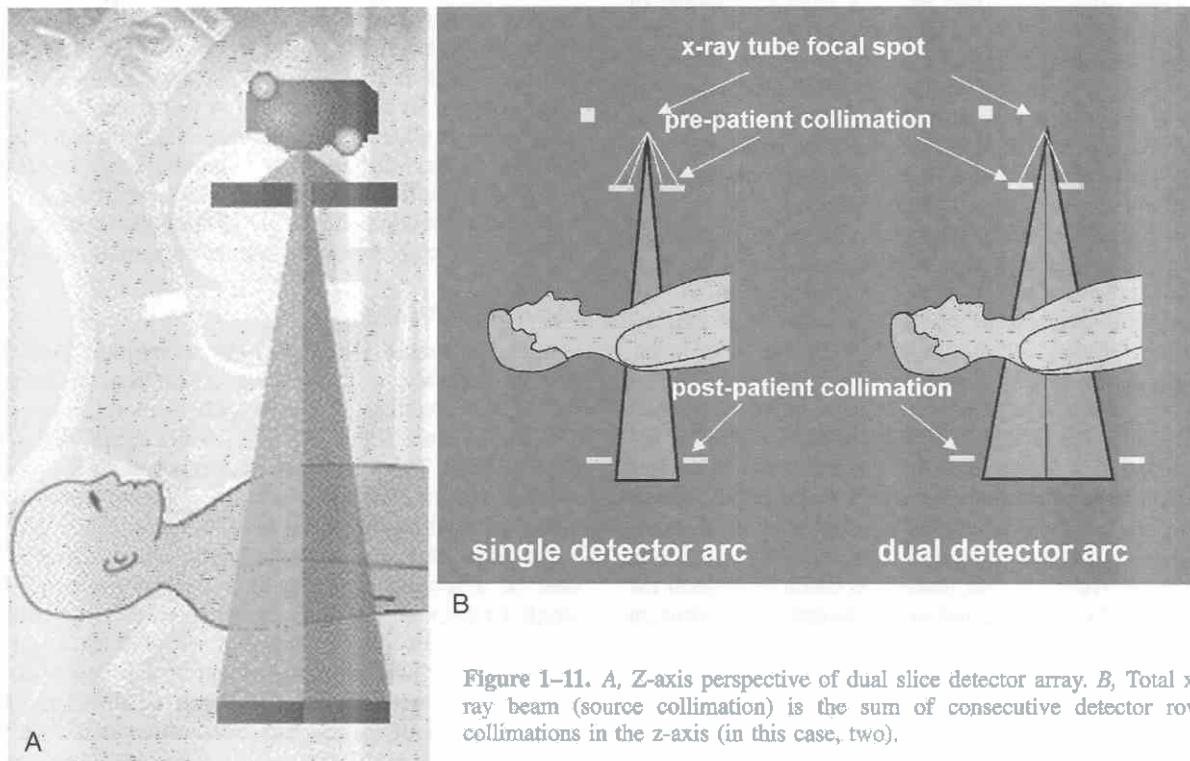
A, Z-axis perspective of dual slice detector array. B, Total x-ray beam (source collimation) is the sum of consecutive detector row collimations in the z-axis (in this case, two).
